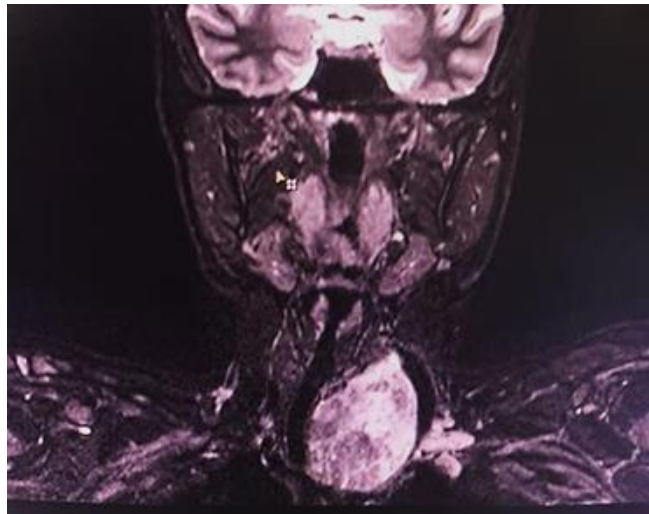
MRI neck showing left thyroid mass with retrosternal extension deviating trachea towards right and causing compressive effects over the structures in the neck.
